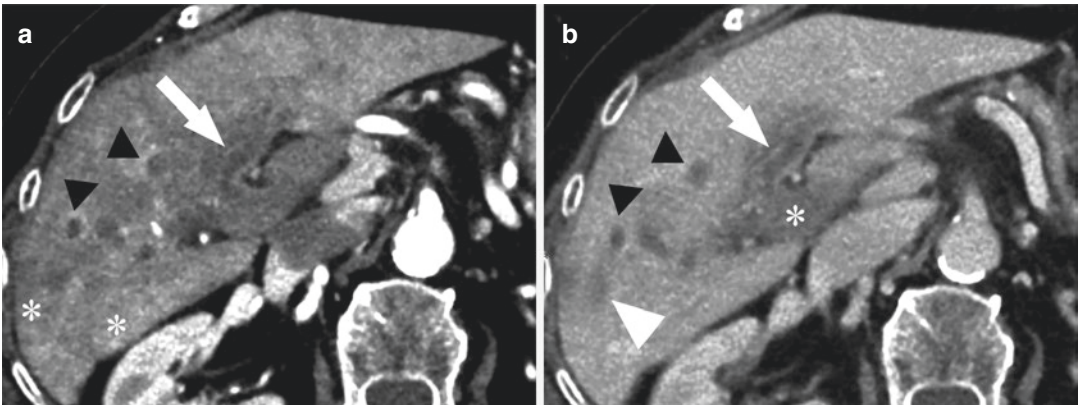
Acute cholangitis. (a) Axial contrast enhanced arterial phase CT image shows inhomogeneous hepatic parenchymal enhancement (*). (b) Axial contrast enhanced portal phase CT image shows portal vein thrombosis (*) and an ill-defined hypoattenuating parenchymal
